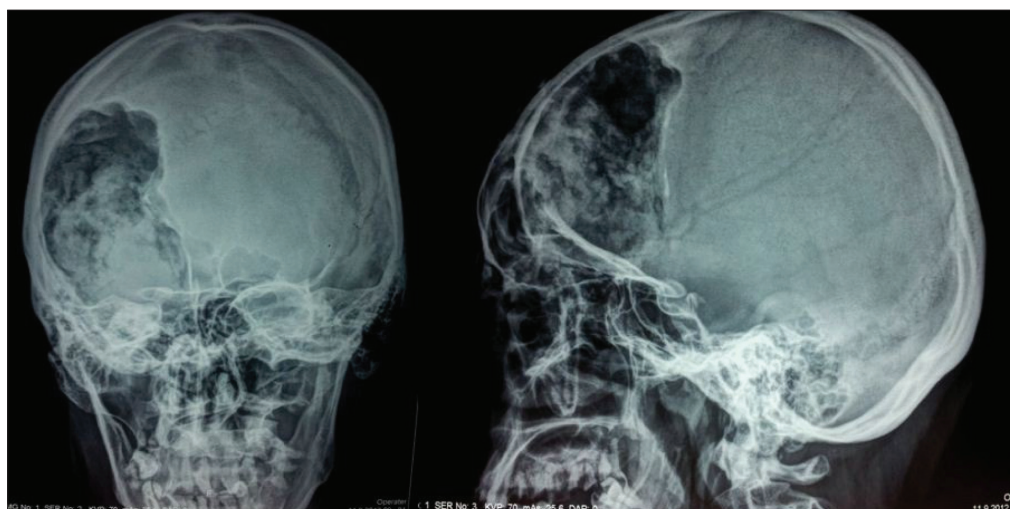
Skull X-ray showing extradural lytic bone lesion.
